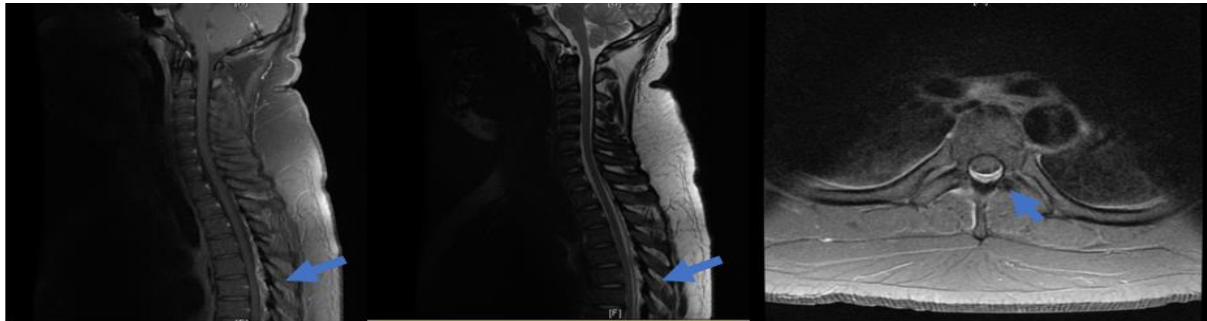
MRI sagittal,axial with contrast. It showed posterior epidural collection
